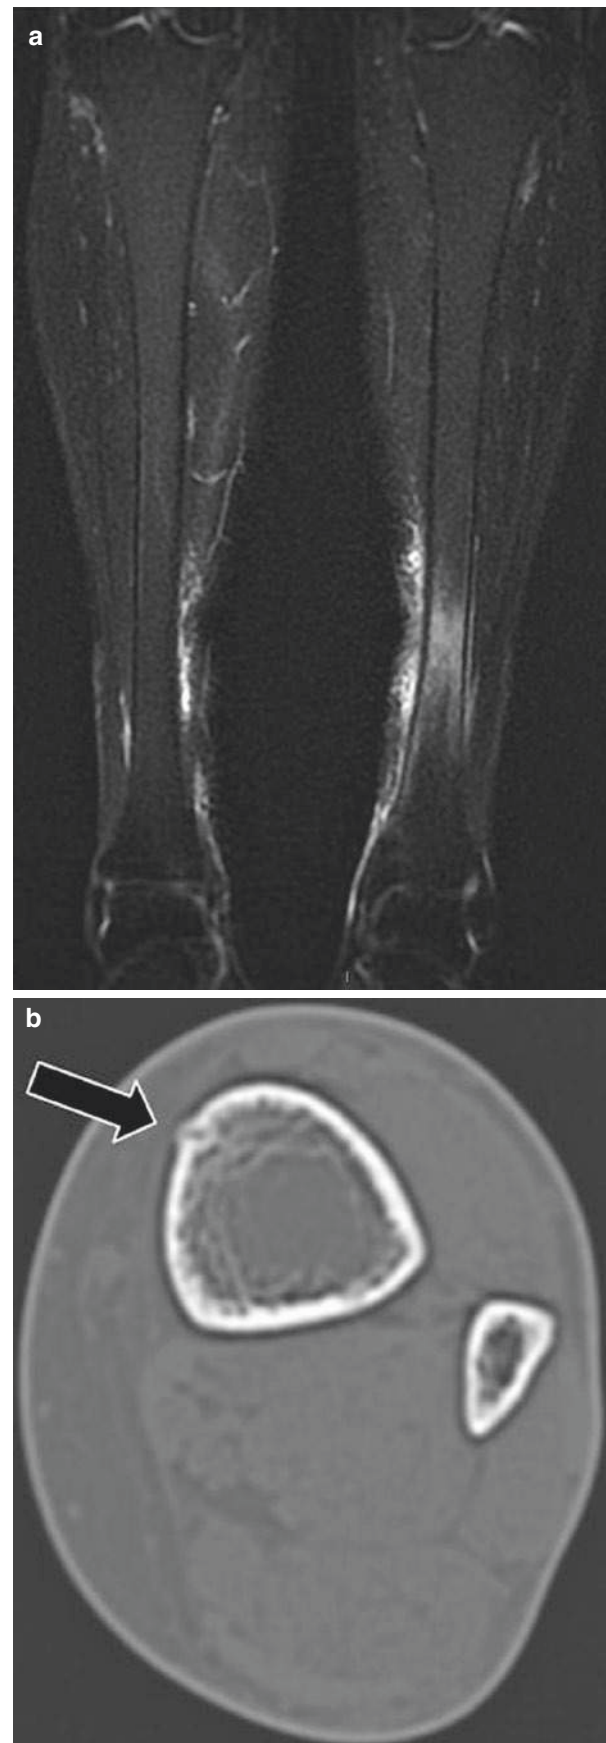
Longitudinal ISF of the left tibia. (a) A coronal STIR image of both tibias demonstrates oedema in the medullary cavity and adjacent soft tissues of the left tibia. (b) A CT image of the left tibia shows a cortical fracture with periosteal and endosteal callus (arrow)
